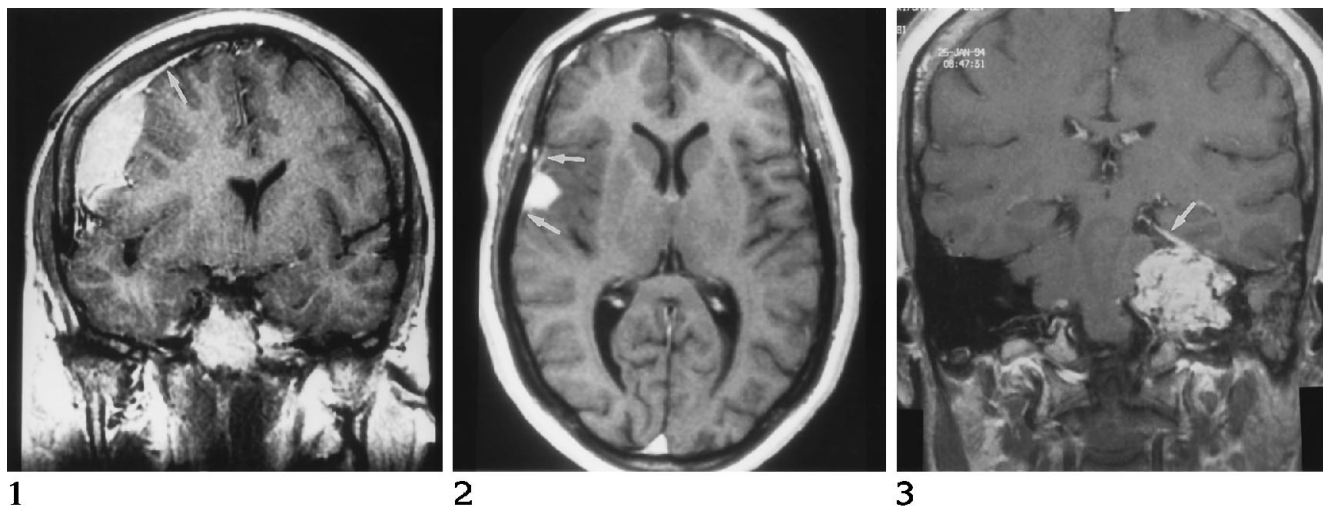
Coronal T1-weighted (450/20/1) image after the administration of gadopentetate dimeglumine shows intense, uniform enhancement of a large, extraaxial mass lesion in the right frontal region, with an associated dural tail (*arrow*). The mass proved to be a primary central nervous system lymphoma of the dura.
